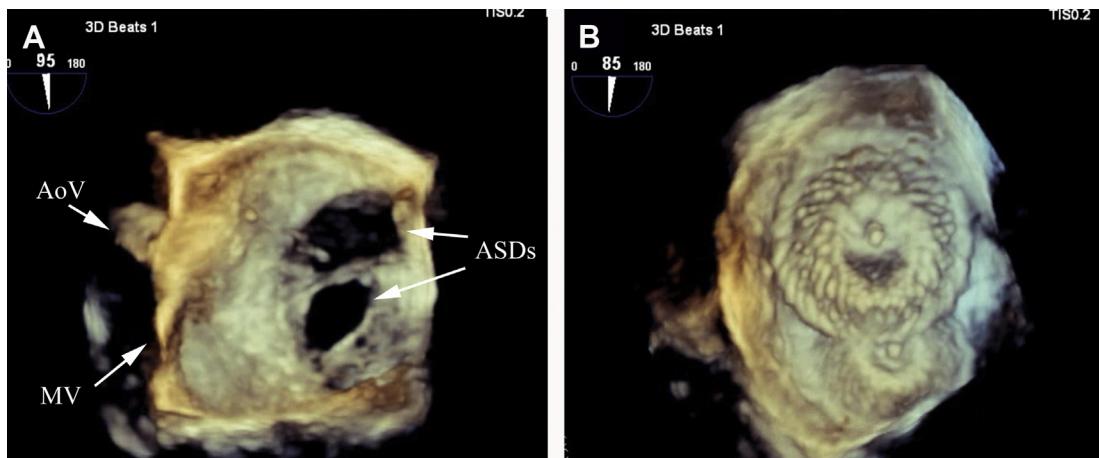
(A) Three-dimensional transesophageal echocardiogram, left atrial view demonstrating 2 large ostium secundum type ASDs, the aortic valve (AoV) and the mitral valve (MV) are labeled for orientation. (B) After closure with 2 Amplatzer septal occlude devices (ASD).
